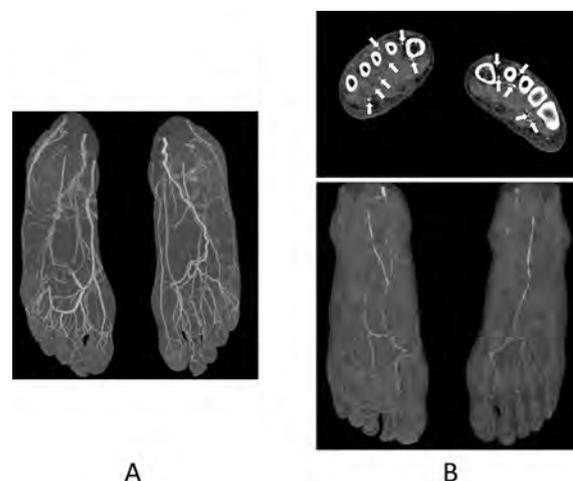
Ultra-high-resolution CT of the digital artery of the foot. The maximum intensity projection (MIP) image without arterial stenosis of the feet shows fine visualization of the digital arteries and pedal arch (A). Axial plain CT image of the feet of a patient undergoing hemodialysis shows severely calcified digital arteries (B, top). The MIP image of this patient shows multiple stenosis or occlusion of the pedal arch and digital arteries (B, bottom).
